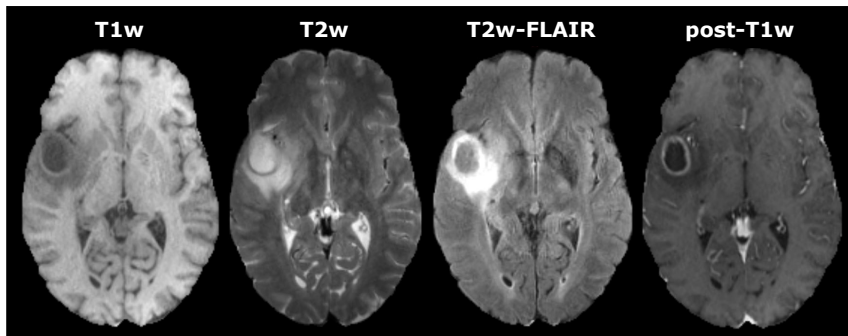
Weighted images included in a standard MRI protocol for glioma assessment. These image modalities are usually acquired, but other modalities could be also included depending on the institution. See how each image modality is able to highlight different properties of the tumor.
